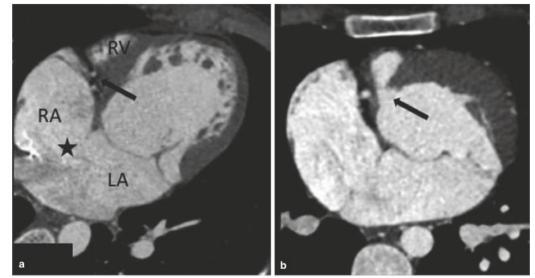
Cardiac CT axial images shows: (a) ASD (black star) and presence of fat in AV right groove (Black arrow). (b) Restrictive VSD (black arrow) and hypoplastic right ventricle. (Nagulakonda and Malhi 2023).
